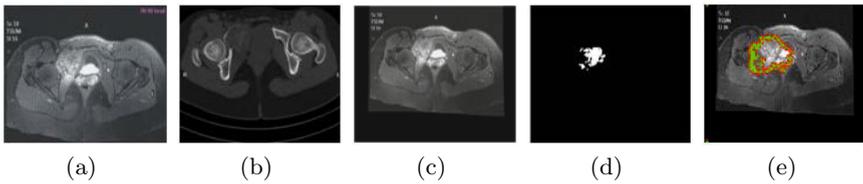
(a) T1 weighted MR image of pelvic, (b) CT image of pelvic, (c) registered image (d) initial region of the tumor region (PFCM classification result), (e) Final segmented tumor region
